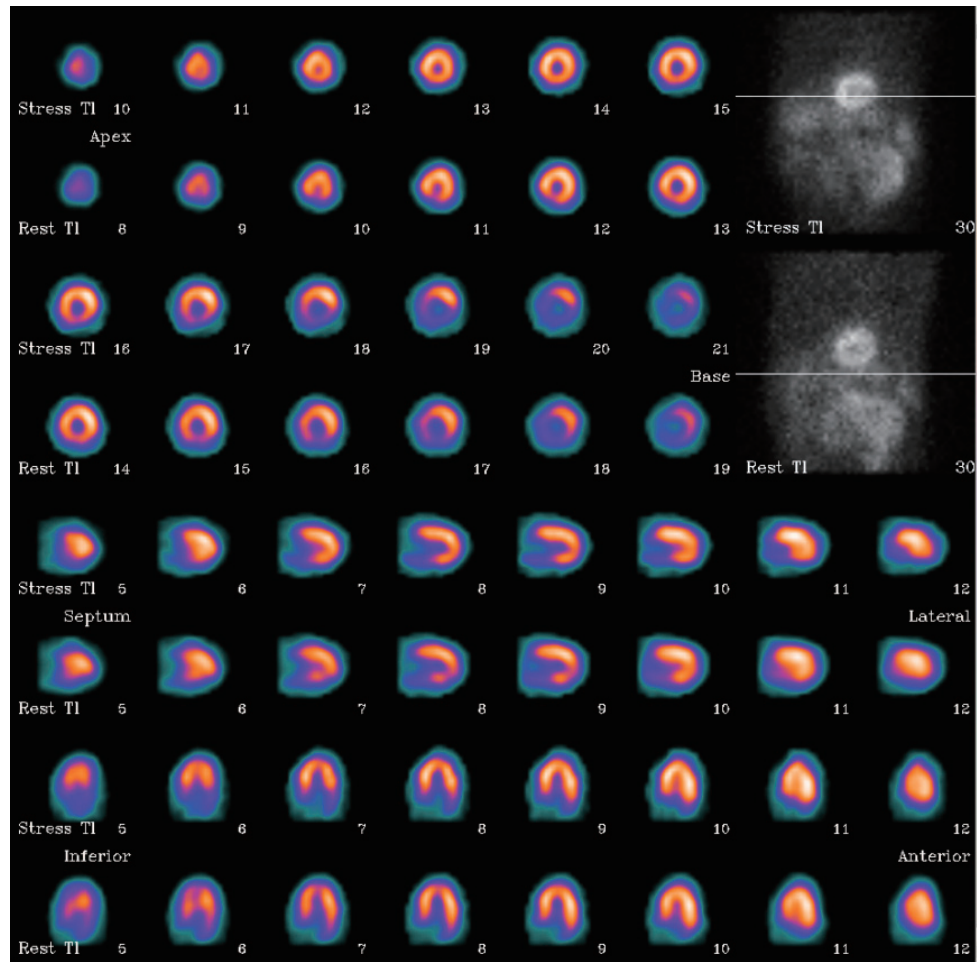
Myocardial perfusion imaging with technetium-99m sestamibi SPECT revealed stress-induced myocardial ischemia in the apical and inferior wall.
